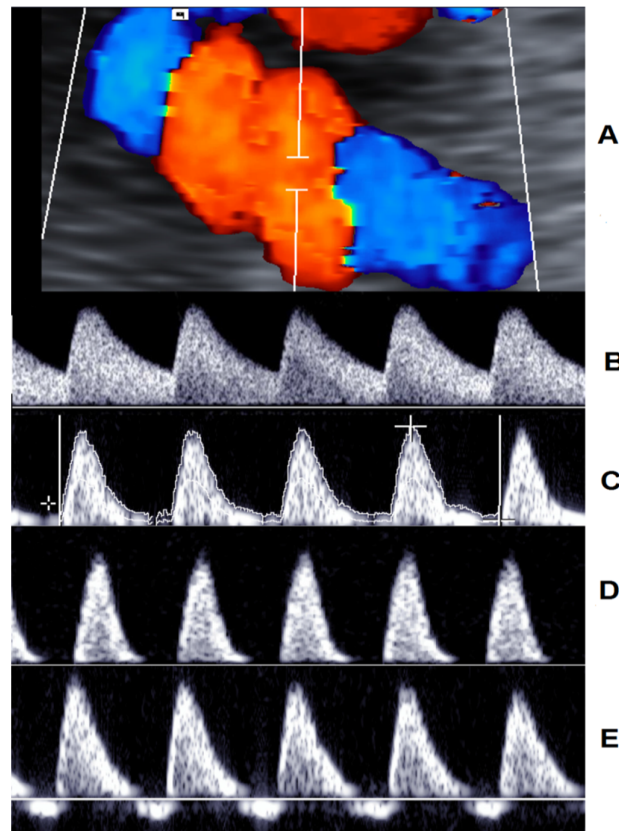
A, Site of insonation of the umbilical artery Doppler. Progressive waveform patterns with advancing severity were: B, normal umbilical artery waveform, C, increased impedance to flow, D, absent end-diastolic flow, and E, reversed end-diastolic flow.
